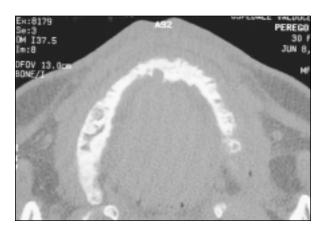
Computed tomography scan showing insufficient width of the maxillary ridge.
